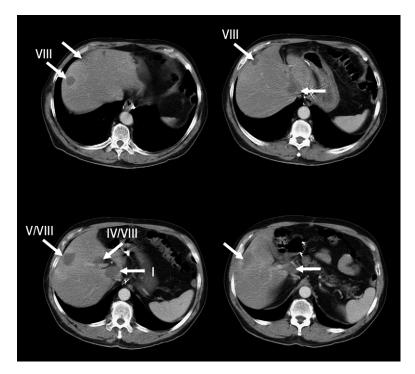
Postchemotherapy portal venous phase CT scans of the second patient taken from a triphasic CT scan performed in July 2002. The scans show the extent of the metastatic disease prior to resection. Hepatic metastases are marked by *white arrows*, and the number indicates the hepatic segment that is involved. Each metastasis is only numbered once.
